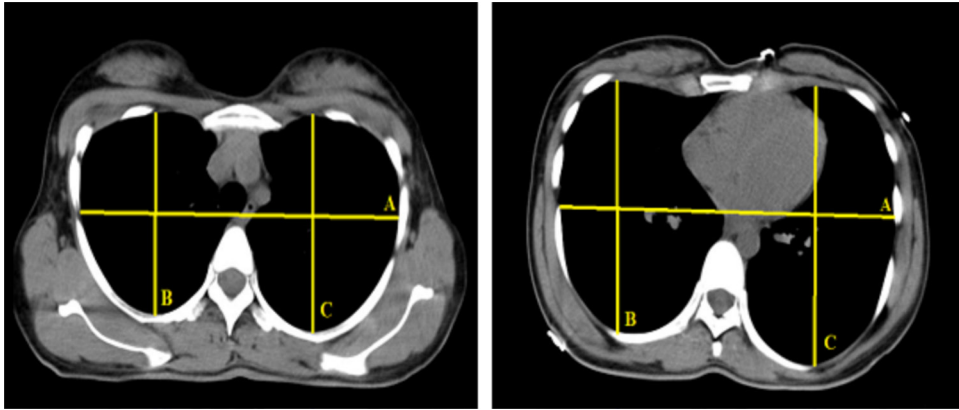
The widest transverse chest diameter measurement (A) and widest anteroposterior chest diameter measurement in both hemithoraces (B, C) on the axial CT T4 and T9 levels
